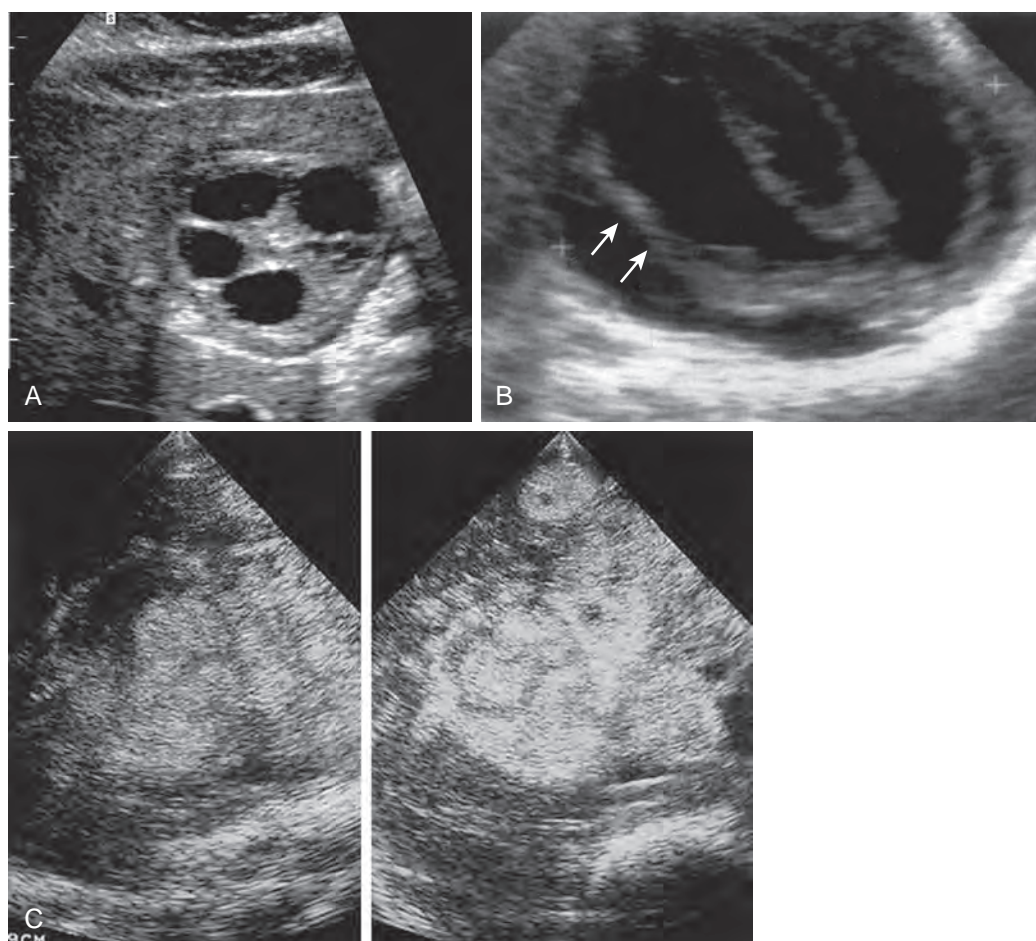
Hydatid disease: sonographic features. A. Longitudinal scan shows a rounded, well-defined, multilocular hypoechoic lesion with echogenic internal septa due to *E. granulosus*. B. Hydatid cyst in the right lobe with wavy bands of delaminated endocyst (water lily sign, arrows). C. *E. multilocularis* cysts. Transverse ultrasound images obtained at different levels of the liver show *E. multilocularis* infection with the typical hailstorm pattern, characterized by multiple echogenic nodules with irregular and indistinct margins. (B and C from Mortelet, KJ, Segatto E, Ros PR: The infected liver: Radiologic-pathologic correlation. *RadioGraphics* 24:937-955, 2004.)
